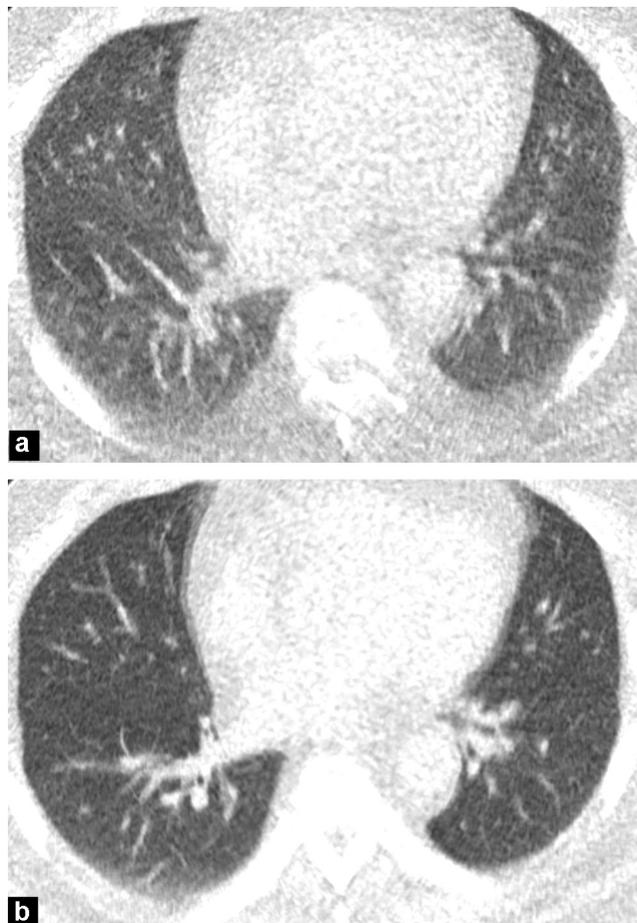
Ultra-low dose CT image of the chest in the transverse plane in (lung window) acquired at 80 kVp (a) and at 135 kVp (b) in a 52-year-old man with a body mass index of 32 kg/m². 135 kVp acquisition (b) is still informative, while the 80 kVp one (a) can be considered non-diagnostic.
